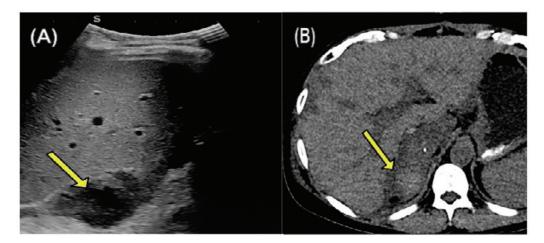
A 41-year-old post-cadaveric liver transplant status (postoperative day [POD] 20) under routine weekly surveillance. Ultrasound (USG) showed heteroechoic hematoma with central hypoechogenicity (A, yellow arrow) corresponding to the hyperdensity in computed tomography (CT) axial images (B).
